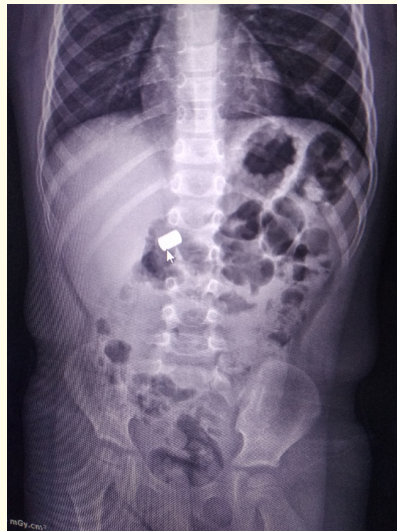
Abdominal radiograph showing metal objects in the abdomen, just right of the midline (Arrow: foreign object).
